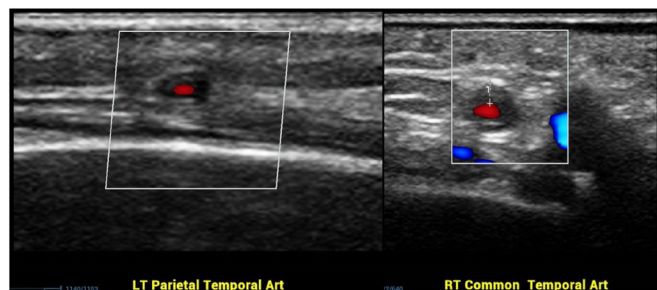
Halo sign on superficial temporal artery Doppler ultrasound.
